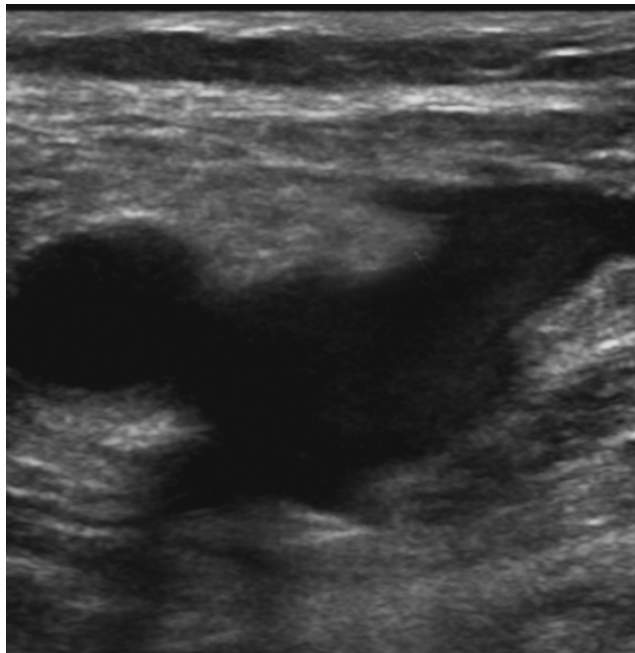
In another image from the study, the rouleaux is seen at the saphenofemoral junction and the size and shape of the echoes are different. In real time echoes move from the saphenous vein toward the common femoral vein. The spectral Doppler (not shown) was normal, indicating no significant obstruction.
